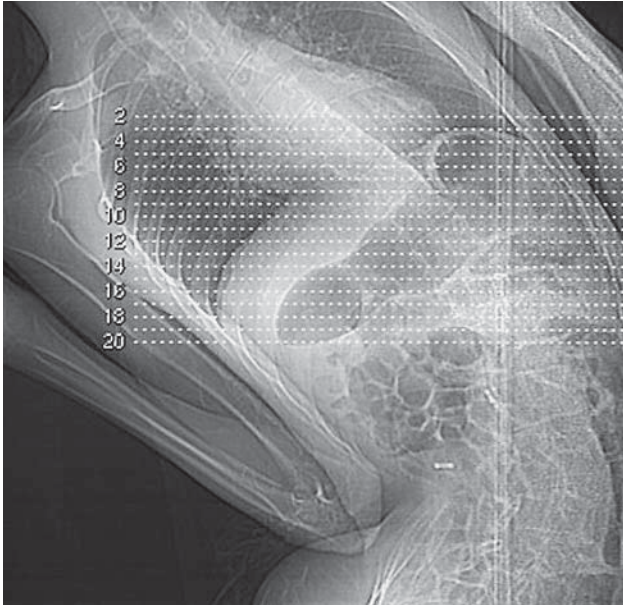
Chest X-ray shows a severe spinal deformity due to scoliosis.
